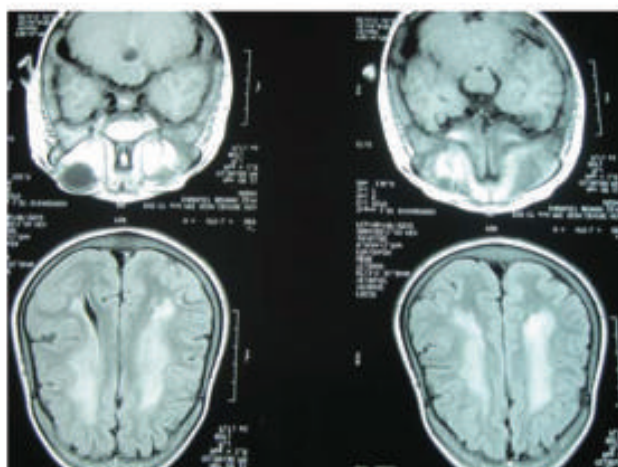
MRI Brain of the older brother
